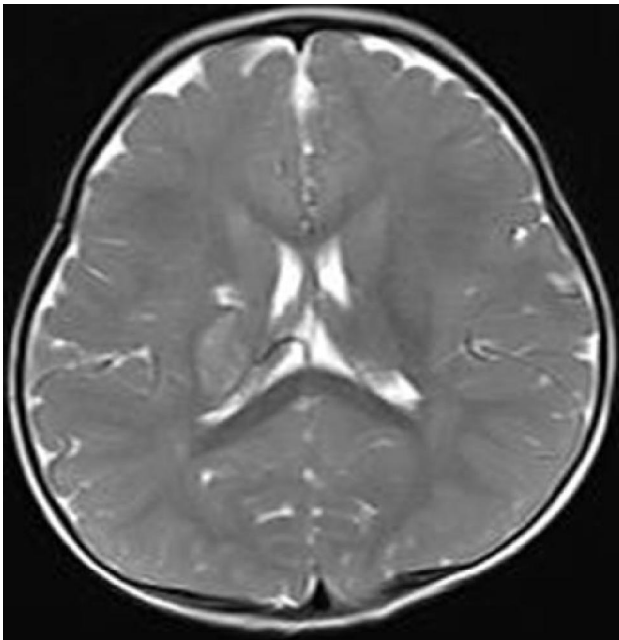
MRI: Axial T2WI shows hyperintense nonhemorrhagic infarct in dorsal portion in right lentiform nucleus and adjoining posterior limb of internal capsule.
